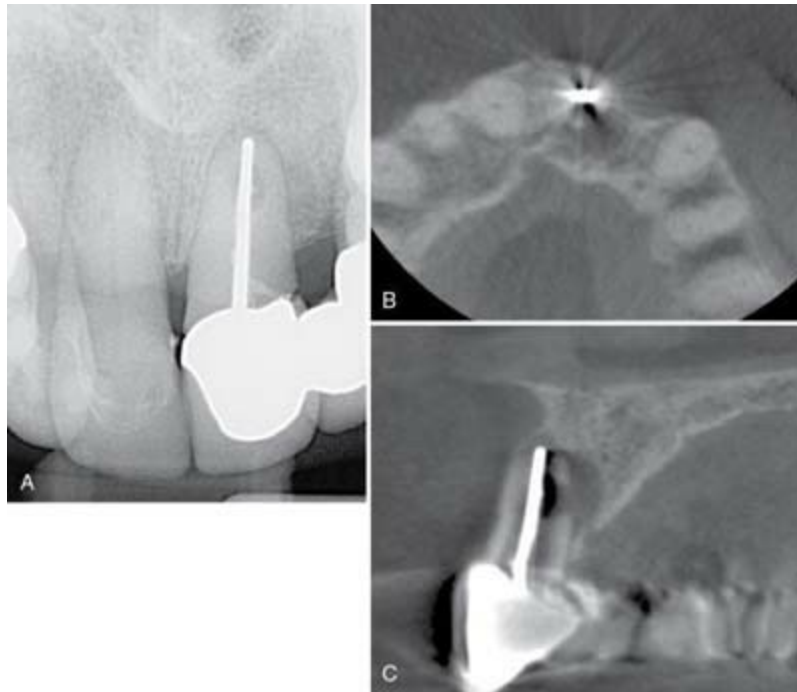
A, Preoperative radiograph showing suspected small area of resorption associated with an endodontically treated tooth filled with a silver cone. B, Axial slice showing how beam hardening artifact from the metallic root filling obscures the image. C, Sagittal view showing very large palatally oriented external root resorption. The prognosis for retention of this tooth was poor and the patient elected to extract it.
